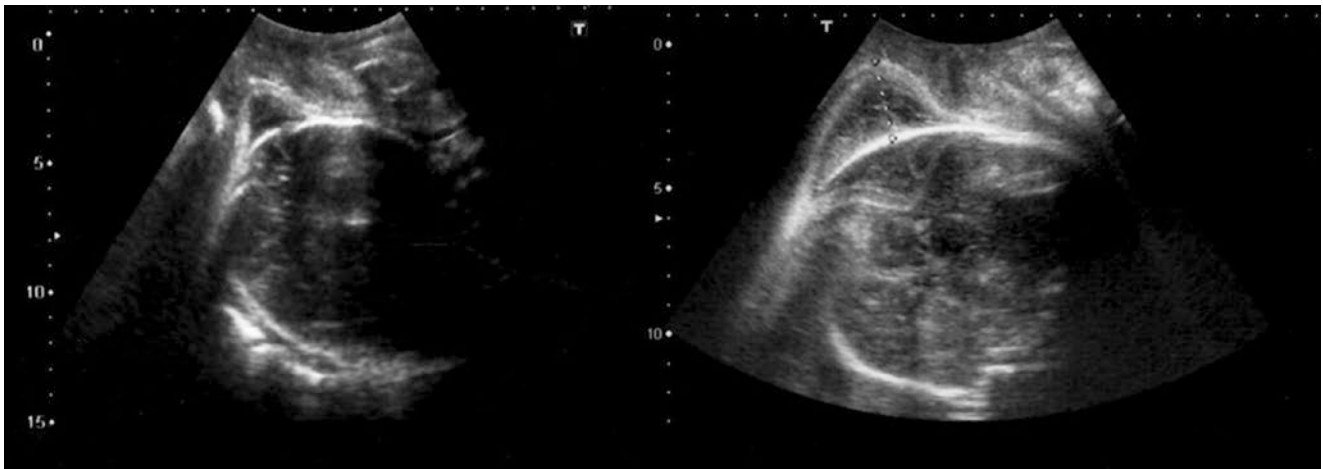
Translabial sagittal ultrasonographic scan of the fetal head in the birth canal with caput succedaneum in dystocic second stage labor. In this case, the fetal head is positioned in left occiput posterior
